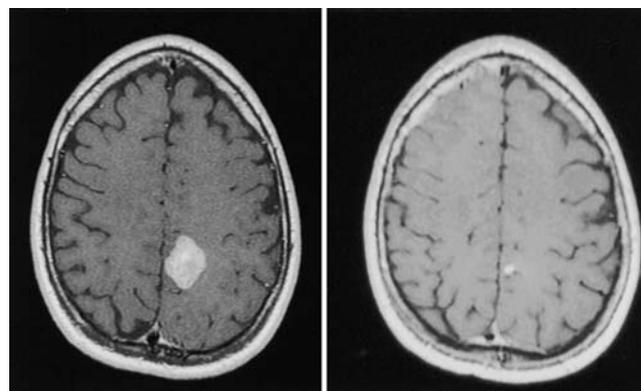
Axial T<sub>1</sub>-weighted contrast-enhanced MR images obtained in a 45-year-old man presenting with headaches and sensory symptoms, demonstrating sensory strip melanoma metastases at the time of GS (*left*) and 6 months later (*right*). A small residual enhancement is seen that was not associated with metabolic activity on fluorodeoxyglucose–positron emission tomography scanning. The patient's condition has improved and he continues an active lifestyle. He was subsequently treated for two new brain metastases.
